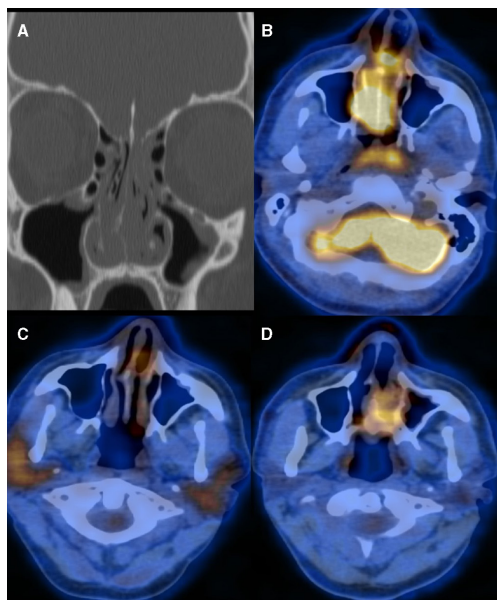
(A) CT showed complete opacity of the nasal cavity on both sides without any bony erosion. (B) PET-scan showed hypermetabolic activity on both sides of the nasal cavity (SUV 8, 9), suspicious of relapsing testicular lymphoma. (C) PET-scan after the treatment of the first nasal relapse showed complete remission without any residual suspicious hypermetabolic activity. (D) PET-scan performed 4 months after the end of the treatment of the nasal relapse showed hypermetabolic activity (SUV 6, 5) in the nasal cavity on the left side, highly suspicious of a second nasal relapse of the NK/T-cell lymphoma. NK, natural killer.
